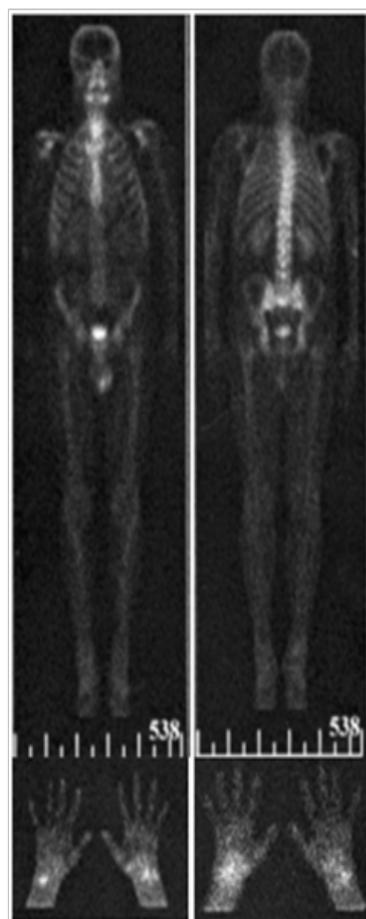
Osteoscintigraphy with TC-99m labeled sodium pyrophosphate (03.03.2006).
